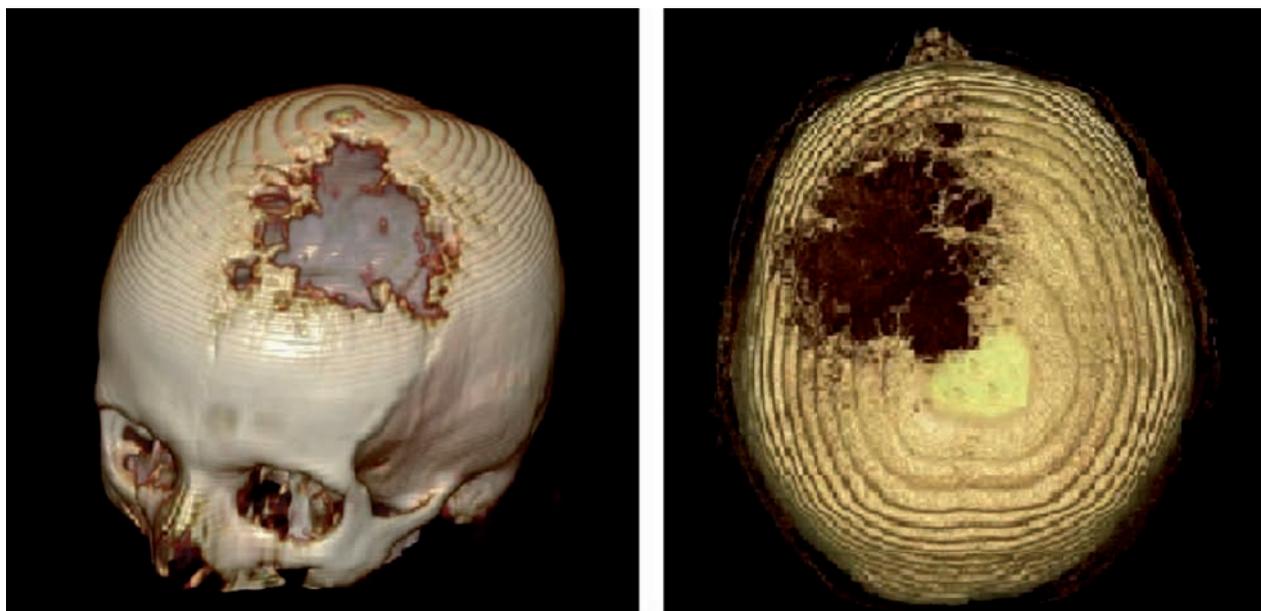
Multiplanar reconstructions of the Computed Tomography to underline the extension of the metastatic lesion
